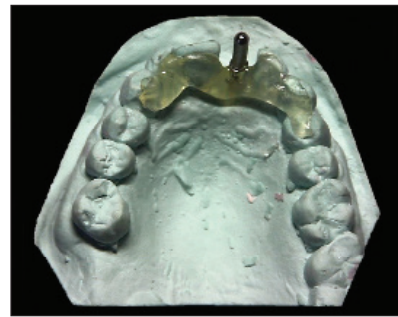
A light-curable resin (primopattern LC Gel [primotec USA]) was applied to capture the 3-mm Guide Sleeve cleat to create the diagnostic guide in preparation for a CBCT scan for implant planning.
